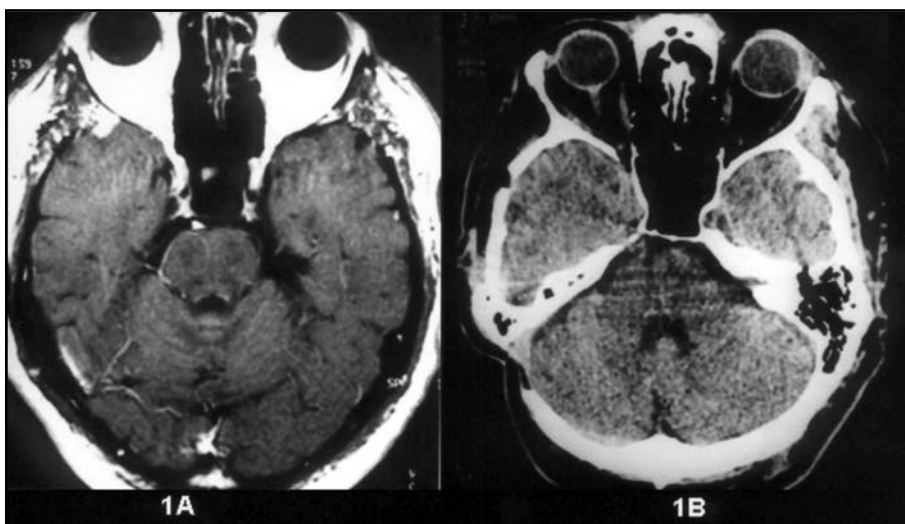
Normal neuroradiological investigation. Post contrast T1-weighted axial MRI scan (1A) and axial CT (1B). The CT was done after the microvascular decompression surgery.
